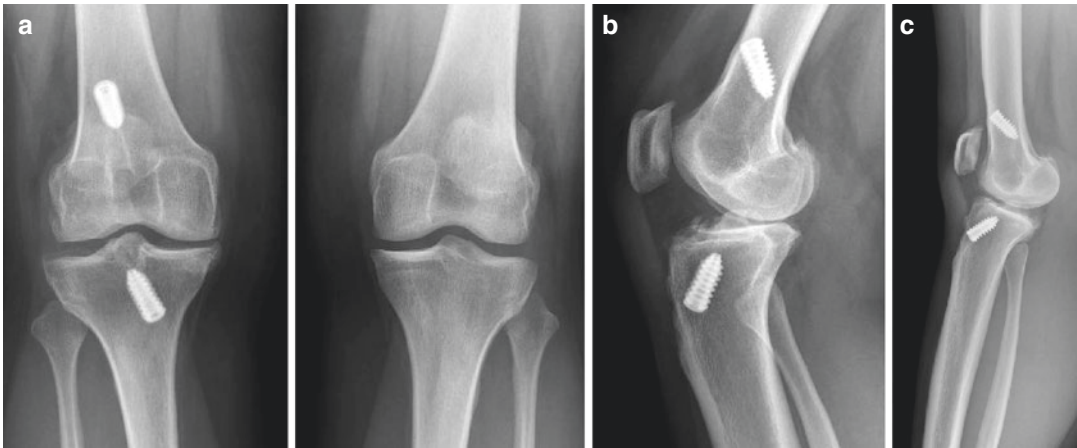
Anteroposterior and lateral radiographs of a 21-year-old female with a previous failed ACL reconstruction and medial meniscectomy at the right knee. Anteroposterior bilateral view (a) shows medial joint line narrowing and initial
